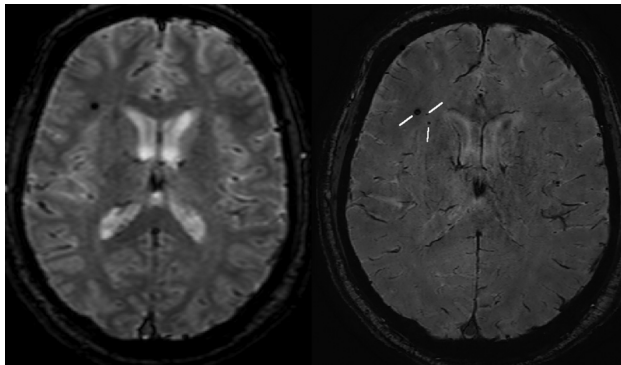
Gradient-echo MR imaging (*left*) and SWI (*right*) acquired in the same subject on a 3T Achieva (Philips Healthcare, Best, the Netherlands) with an 8-channel sensitivity encoding head coil and sensitivity encoding reconstruction of multichannel data. The gradient-echo scan shows 1 microhemorrhage when the more sensitive SWI scan detects 3.
